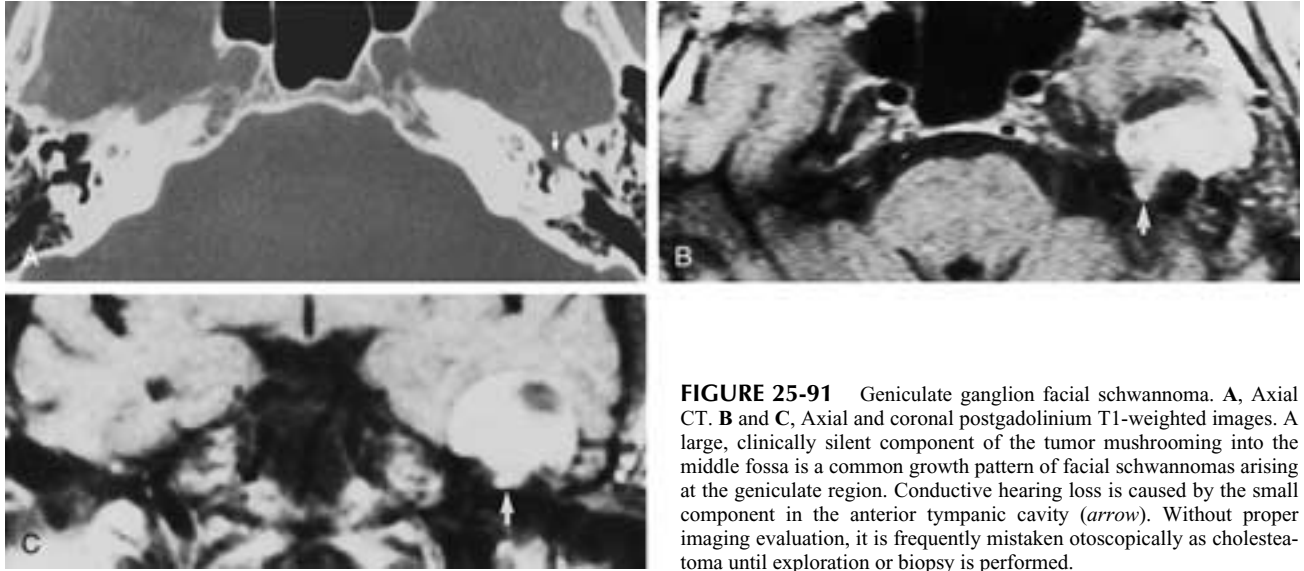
Geniculate ganglion facial schwannoma. A, Axial CT. B and C, Axial and coronal postgadolinium T1-weighted images. A large, clinically silent component of the tumor mushrooming into the middle fossa is a common growth pattern of facial schwannomas arising at the geniculate region. Conductive hearing loss is caused by the small component in the anterior tympanic cavity (*arrow*). Without proper imaging evaluation, it is frequently mistaken otoscopically as cholesteatoma until exploration or biopsy is performed.
